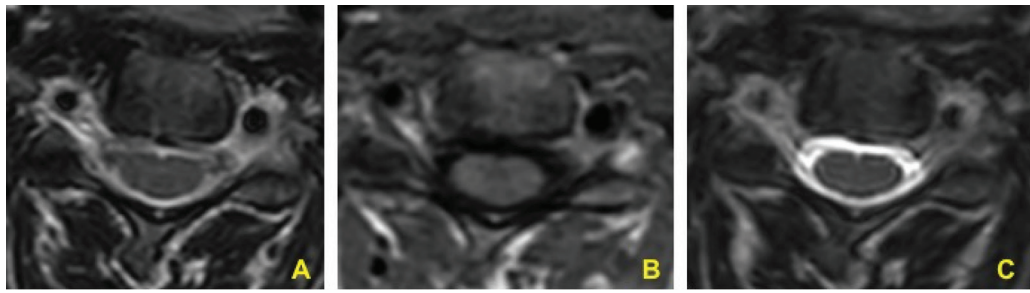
A 52-year-old female patient with cervical radiculopathy. MRI shows grade 0 cervical neural foramen stenosis (no CNFS) in (A) axial 2D T2W image, (B) axial 3D T1W image, and (C) axial 3D T2W image.
